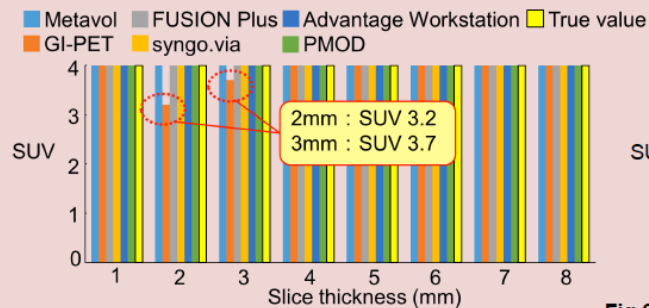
Comparison of SUVmax between 6 software programs
